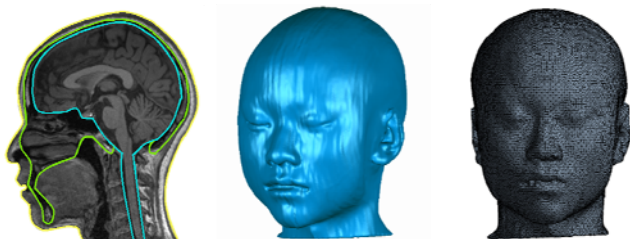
Computational modelling stages. MRI scan (left), digitized geometry (middle) and the meshed geometry (right) is shown.
